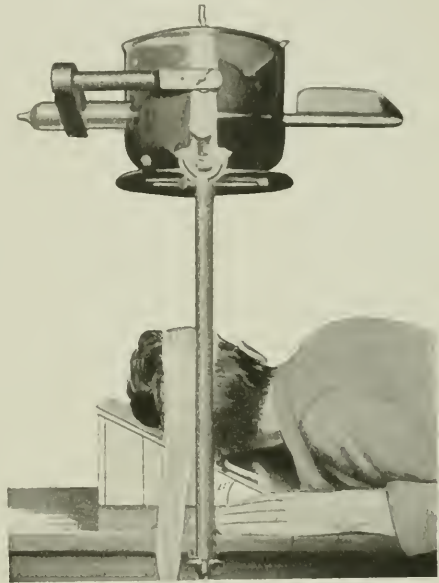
Position for radiography of the mastoid region by Pirie's method.
